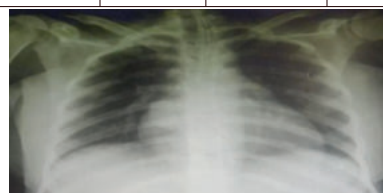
Chest X-ray PA view of case number 8 on admission
